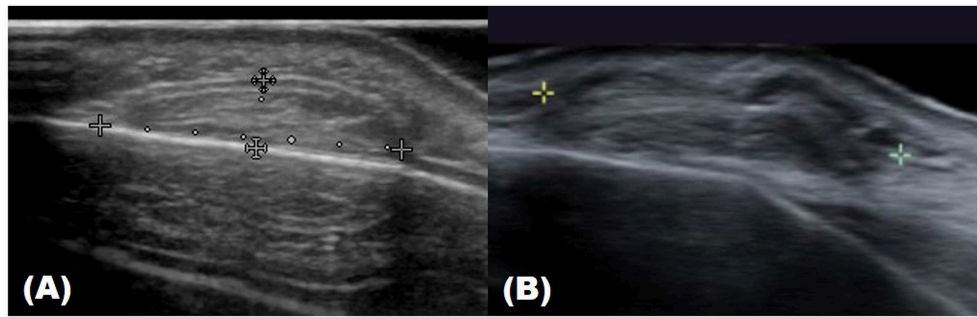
Ultrasound image of forehead lipoma. (A) Submuscular layer. (B) Subcutaneous layer.
